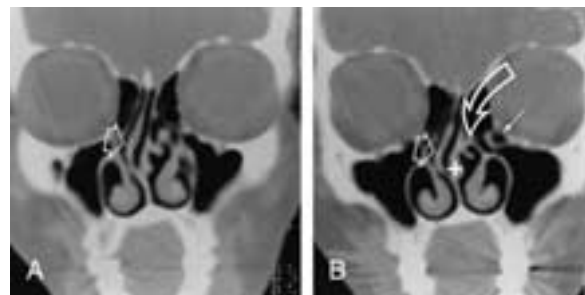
Medially curved uncinate process. A and B, Coronal CT images through the ethmoid sinuses show a prominent right-sided deviation of the nasal septum (*straight open arrow*). Note the medially curved left uncinate process (*curved open arrow*), which is medially displacing the left middle turbinate (+) and obstructs the left middle meatus. A left-sided Haller (infraorbital ethmoid) cell is present (*small arrow*).
